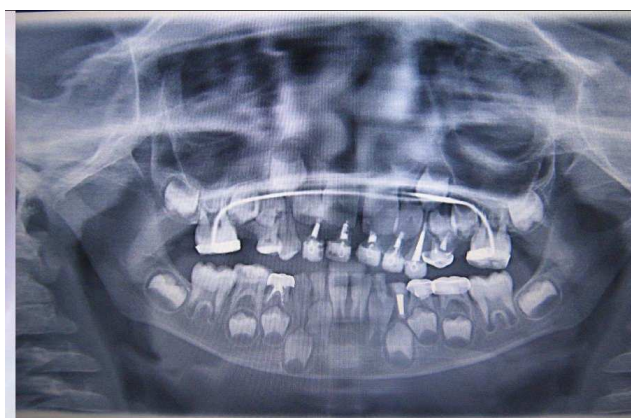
Radiographic view of the patient.
